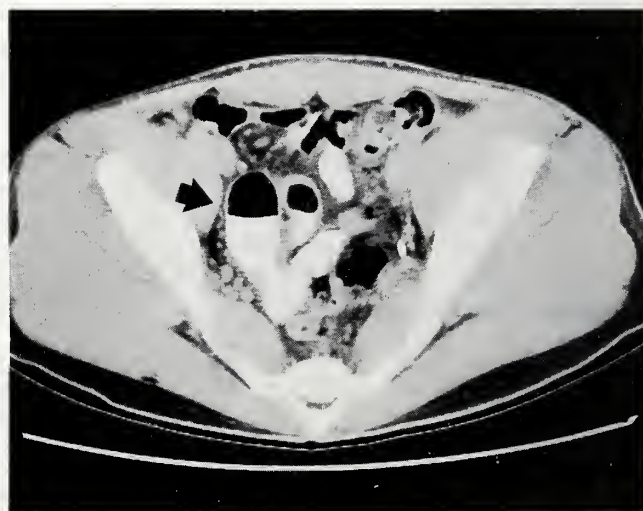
Delayed CT image of mid-pelvis, showing oral contrast medium and air in mass attached to small intestine.
